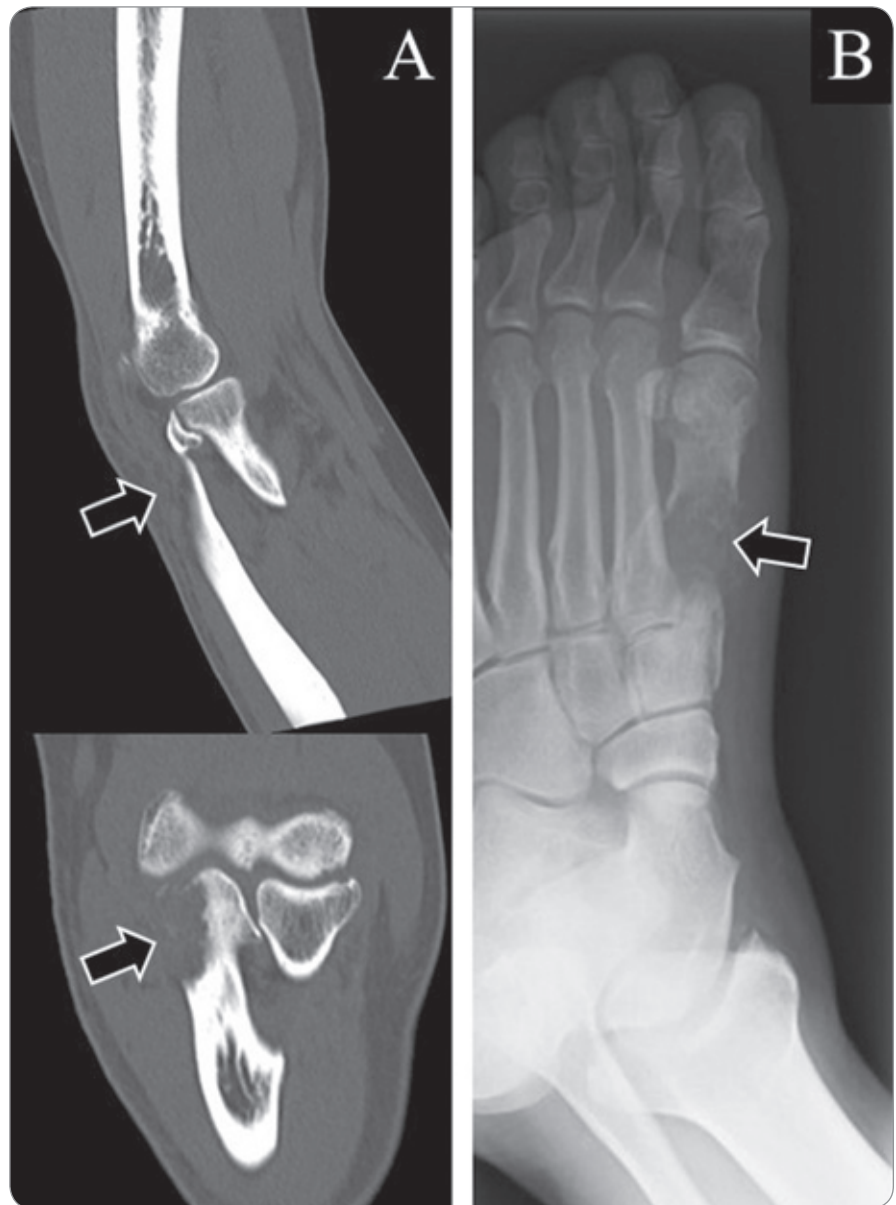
CT scan showed an osteolytic change (arrows) in radius (A) and left metatarsal bone (B) due to bone metastasis.
